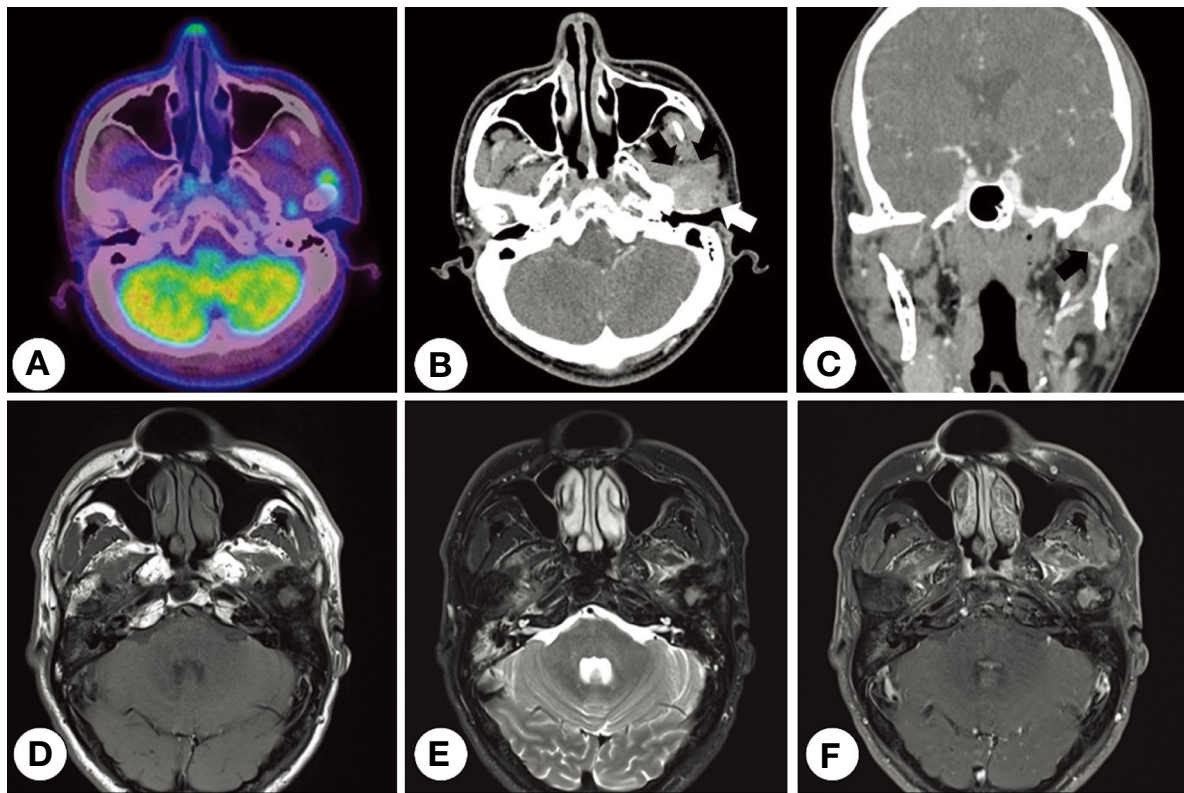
Imaging features of tenosynovial giant cell tumor (Case 3). A. An outside PET/CT image taken before the condylectomy shows vigorously high uptake surrounding the left mandibular condyle. B. On the contrast-enhanced axial CT image, irregular margined enhancing mass around the resected condyle was seen (black arrow). The lesion was in contact with the outer margin of the external auditory meatus (white arrow). C. The mass mentioned above with resected end of the mandibular condyle neck is shown on the coronal view of the contrast-enhanced CT image (black arrow). D-F. On Axial MR images, the lesion reveals iso signal intensity (SI) on T1 weighted, slightly high SI on T2 weighted MR images with heterogeneous enhancement. Its peripheral dark rim suggests hemosiderin deposition around tumor mass.
